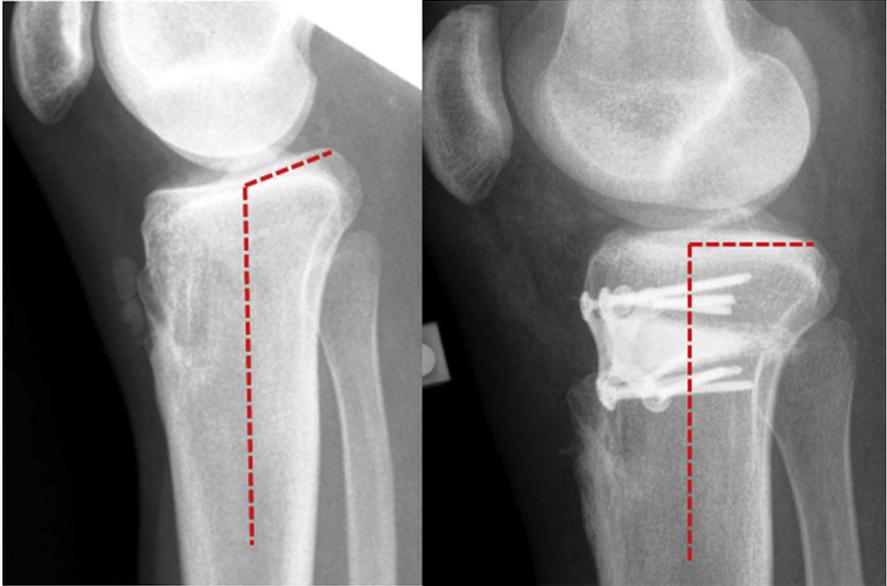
Anterior opening-wedge high tibial osteotomy to increase posterior slope. On the left, preoperative lateral radiograph with negative posterior tibial slope. On the right, postoperative lateral radiograph with posterior tibial slope of 0°.
